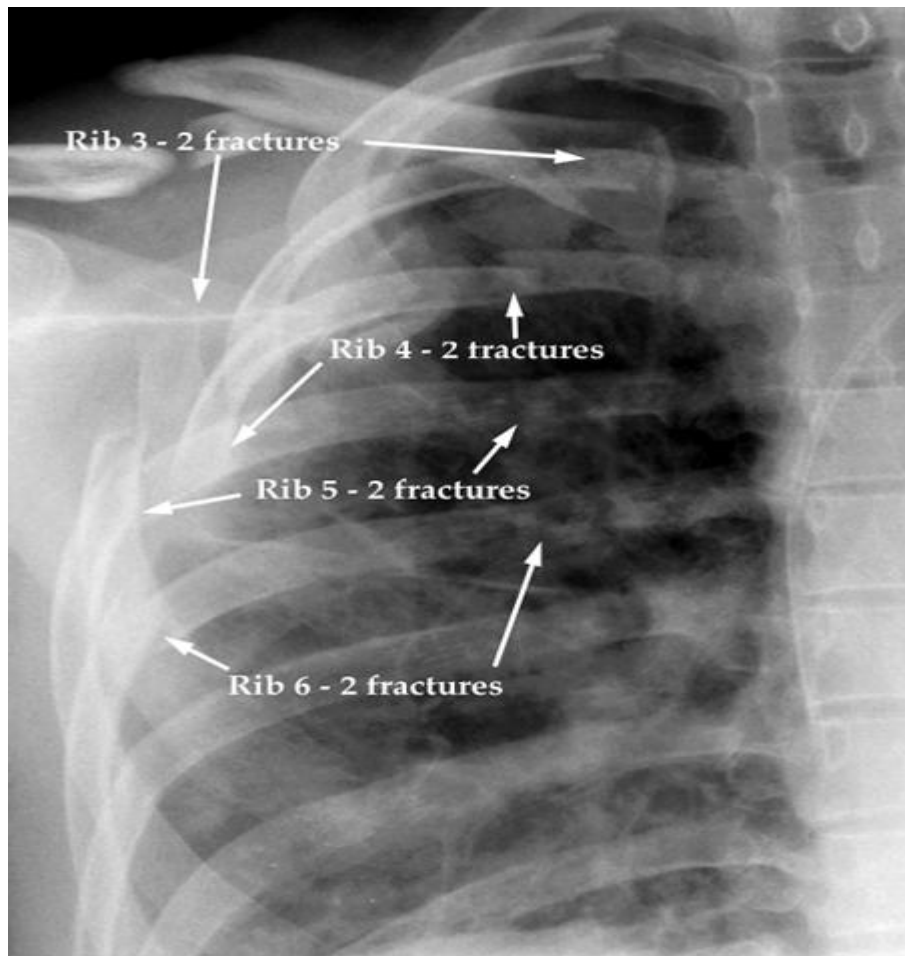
Flail chest. Chest X-ray in PA view showing multiple ribs fracture both: anteriorly and posteriorly.
